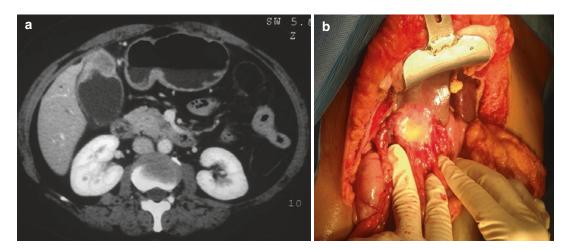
Gallbladder cancer at fundus (a) on CT (b) at operation
